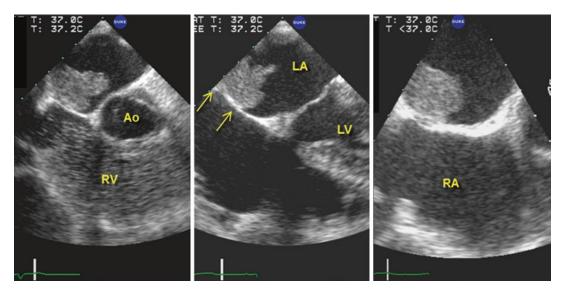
Not all left atrial myxomas are anchored at the ovale fossa. This figure depicts the amorphous character of some myxomas in these transesophageal echo images at different points in the cardiac cycle in a patient with a left atrial myxoma anchored quite posteriorly. Note
